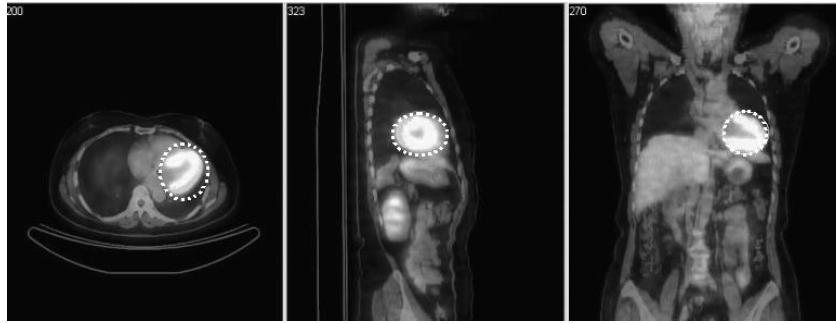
Example of a three-dimensional ROI (*dotted ellipse*) on the fused PET/CT image to measure the SUV of the whole left ventricle.
